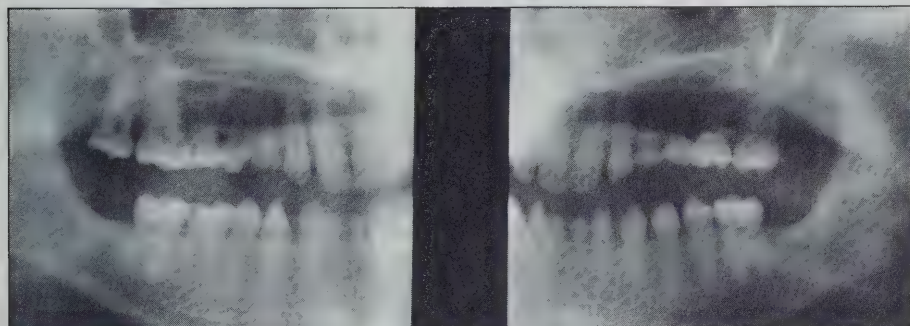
Panoramic radiograph (left to right). Note numerous missing teeth, particularly the lower central incisors.
